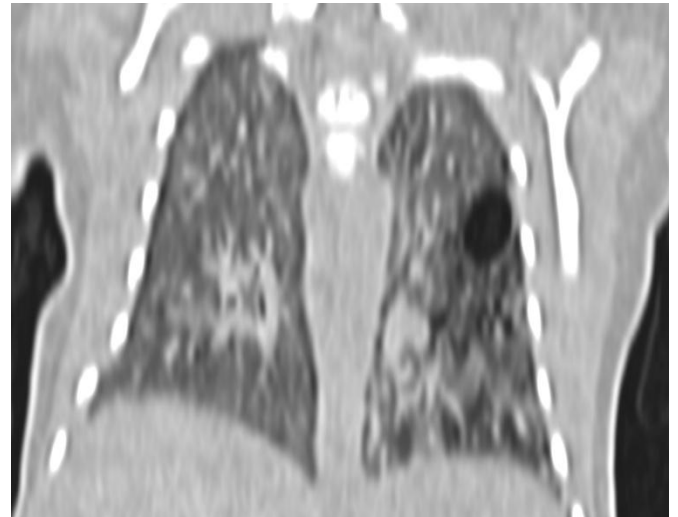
CT scan dated 02/07/2026 in coronal lung window – showing thin-walled cyst in superior basal segment of left lower lobe which is compatible with hybrid lung disease in association with features of pulmonary sequestration.
